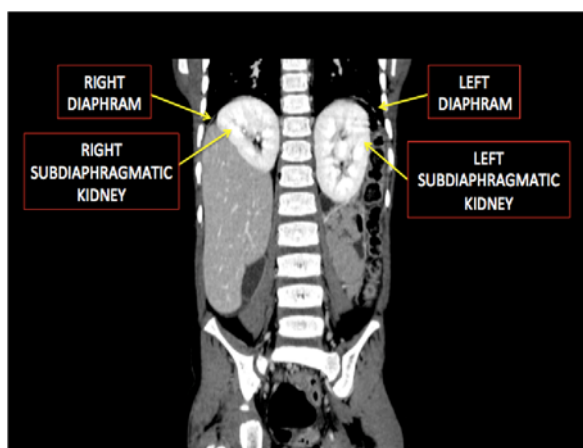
Contrast enhanced CT scan (coronal reconstructed image) shows bilateral subdiaphragmatic kidneys.
